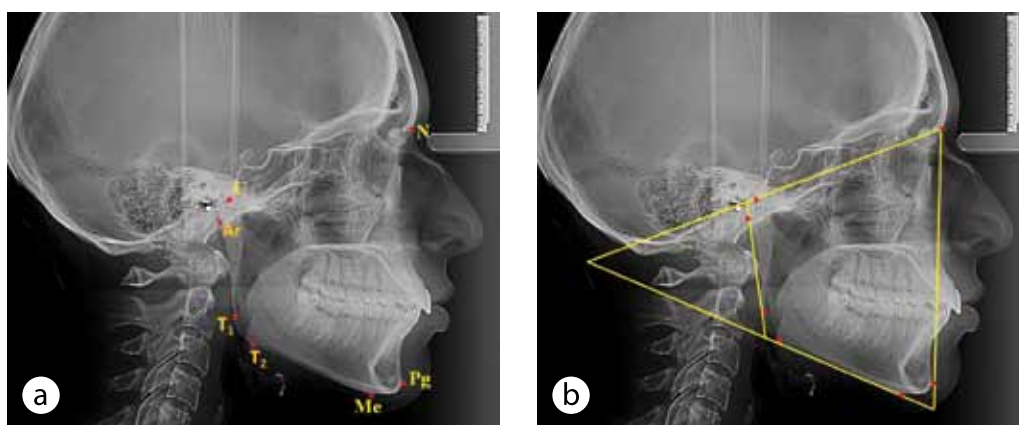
The main points (a) and the line (b) used as the major reference points for comparing radiographs.
